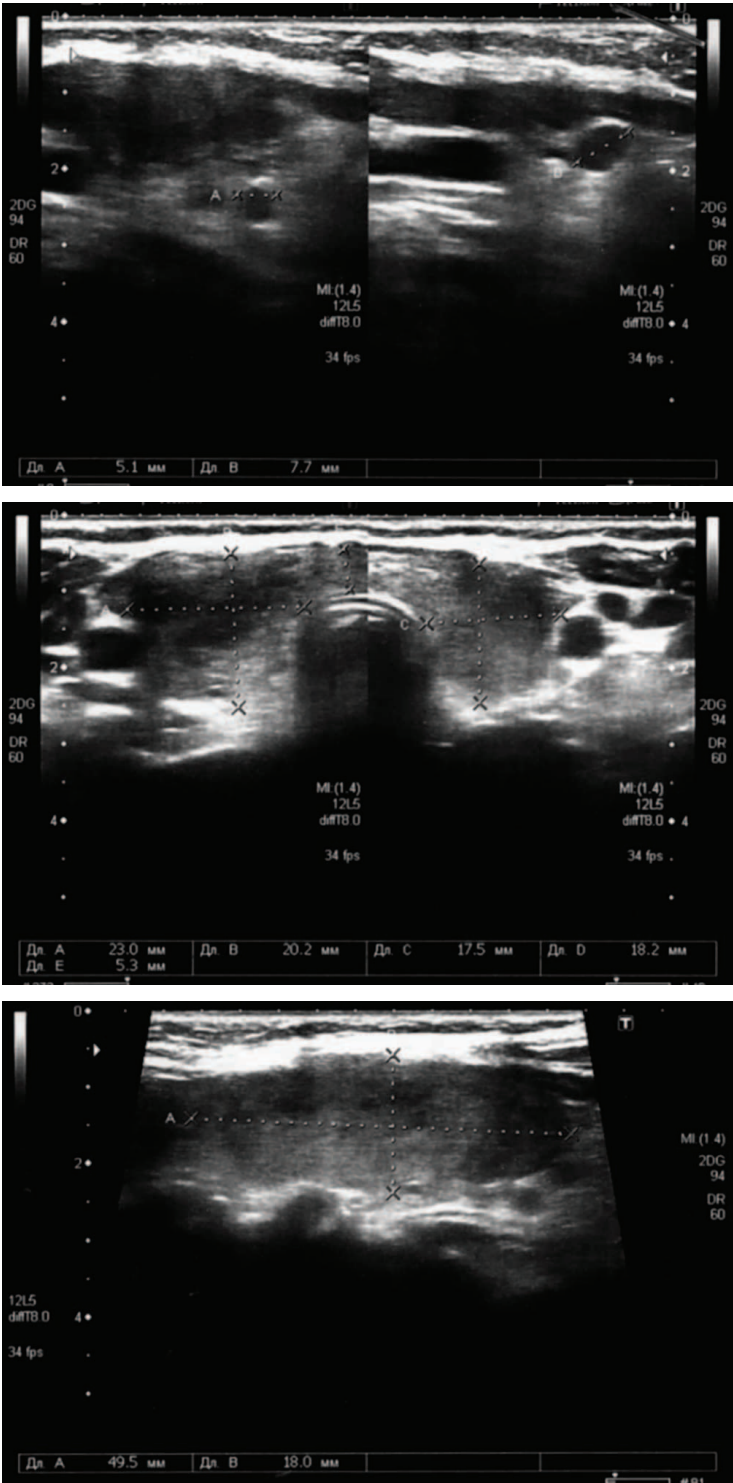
Thyroid ultrasound 25.04
